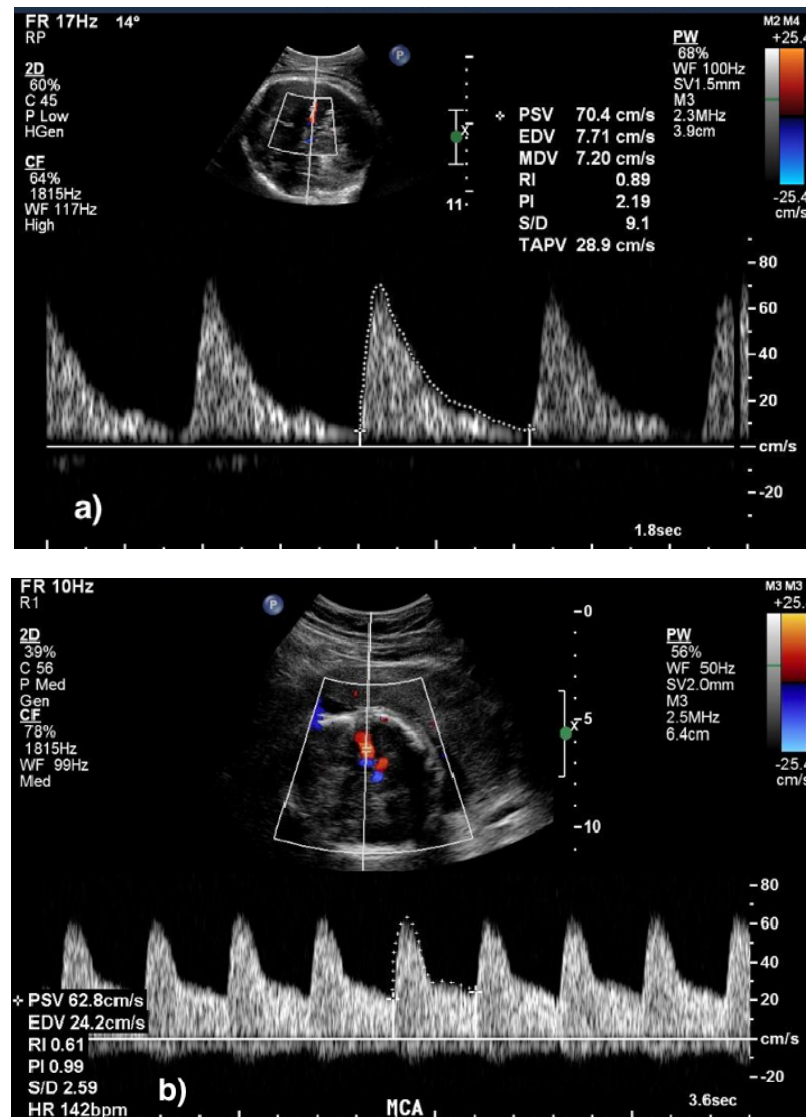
Example of middle cerebral artery doppler in a normal and an IUGR foetus. a) Middle cerebral artery doppler in a 37-weeks normal foetus. b) Middle cerebral artery doppler in a 36-weeks IUGR foetus with elevated diastolic flow, therefore, lower pulsatility index.
